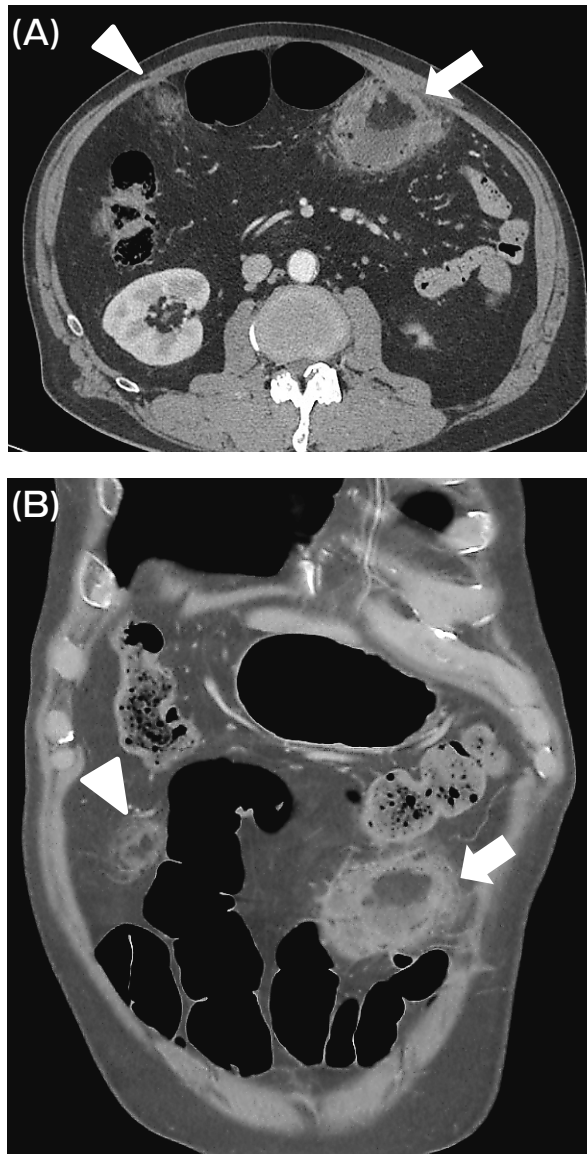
Axial (A) and coronal (B) contrast-enhanced CT images before drainage showed a thick encapsulated fluid collection containing a fat component suggestive of an omental infarction with infection (arrow) and an ill-defined area of increased density on the right side in the same slice as the above lesion (arrowhead).
